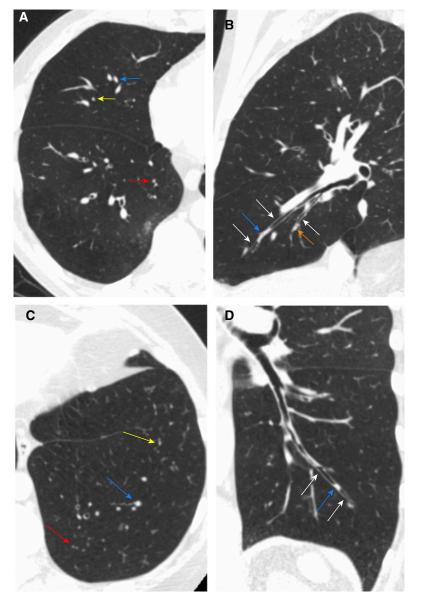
Large and small plugs are identifiable on computed tomographic scans of the lungs. (*A* and *B*) Axial (*A*) and coronal (*B*) oblique images through the right lung. In *A*, three subsegmental mucus plugs are visible in the right middle lobe medial segment (blue arrow), lateral segment (yellow arrow), and right lower lobe medial basal segment (red arrow), with complete opacification of the airways. In *B*, the blue arrow corresponds with the same plug as in *A*, which completely opacifies the airway lumen, with patent airway proximal and distal (white arrows). An additional plug in the same segment is also visible on this image (orange arrow). (*C* and *D*) Axial (*C*) and coronal (*D*) oblique images through the left lung. In *C*, three mucus plugs are visible in the left lower lobe posterobasal (red arrow), lateral basal (blue arrow), and anteromedial (yellow arrow) segments. In *D*, the blue arrow corresponds with the same plug in the lateral basal segment as in *C*. Note the complete occlusion of the airway, which is patent proximal and distal to the plug (white arrows). Also note that more proximally, there are nonocclusive filling defects in the airway lumen, which are not counted as plugs.
